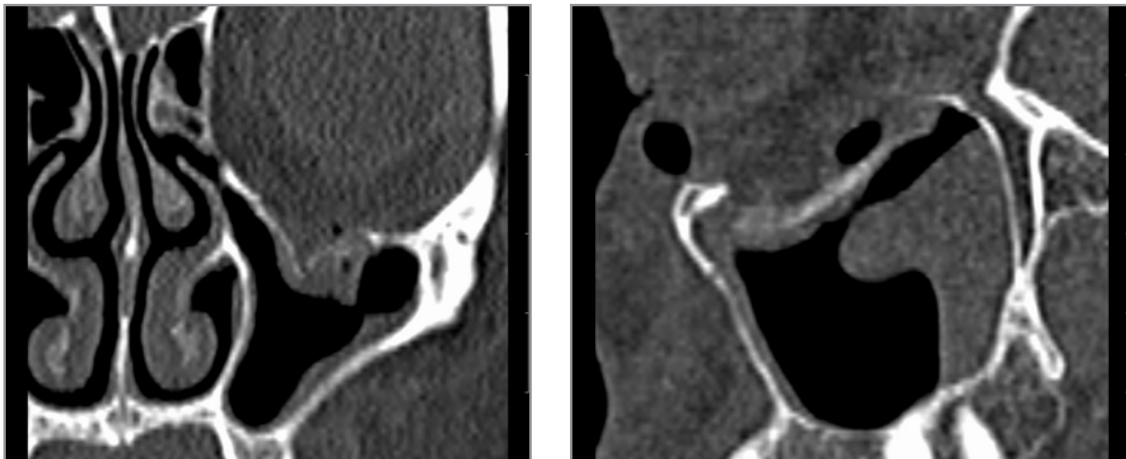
Fracture of the superior wall of the maxillary sinus (X-ray diagnosis - SCT)
